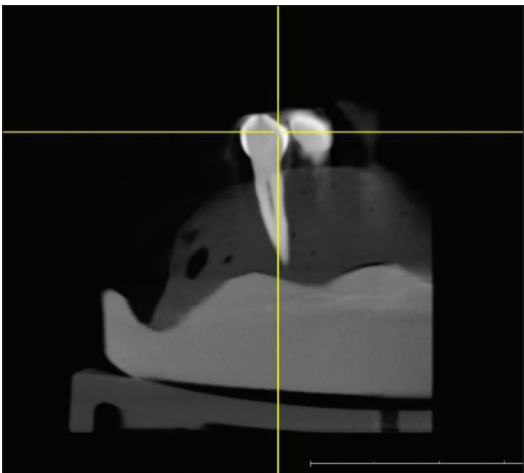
Preoperative cone-beam computed tomography scan
